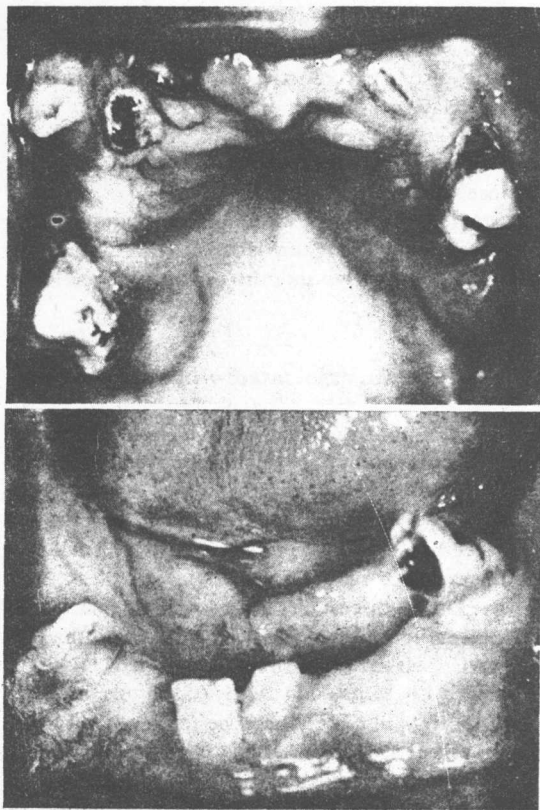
Cleido-cranial dysplasia. The upper and lower jaws of a patient of forty-one. Most of the missing teeth are still embedded in the jaws as shown in the radiographs in Chapter 15.
